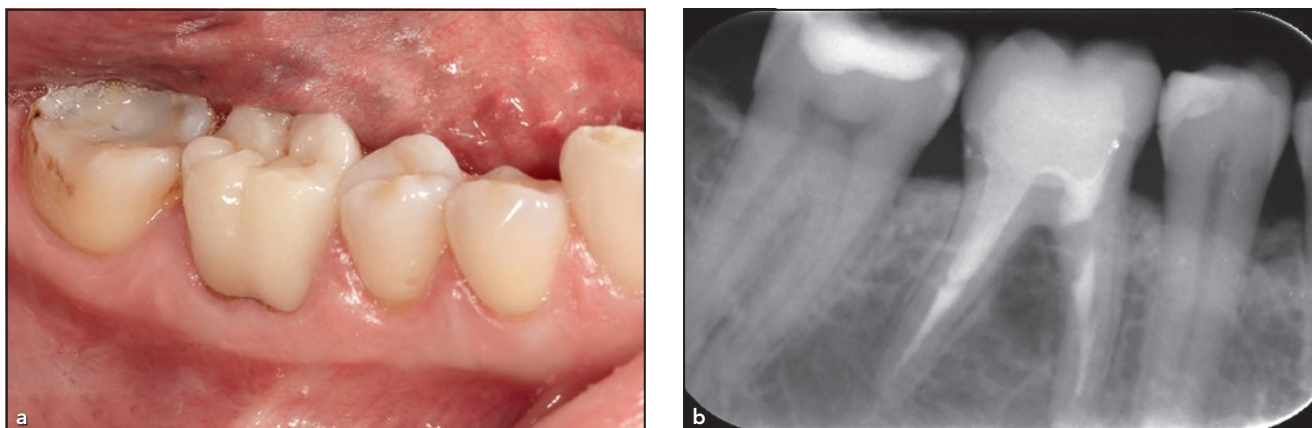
(a) Initial clinical situation of a fractured mandibular first molar. (b) Radiograph exhibiting signs of infection in the furcation area, confirming tooth fracture.
